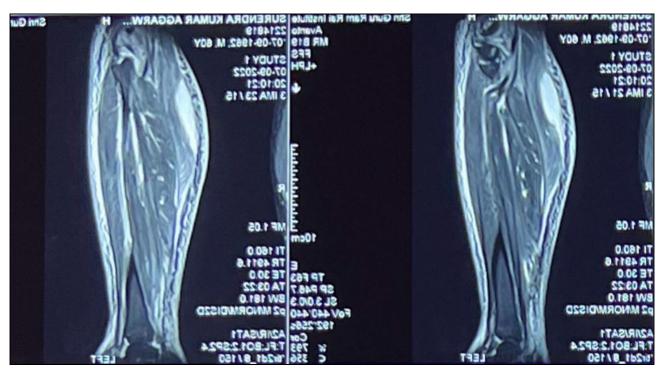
Sagittal T2-weighted image showing hyperintense fluid filled area in the calf
